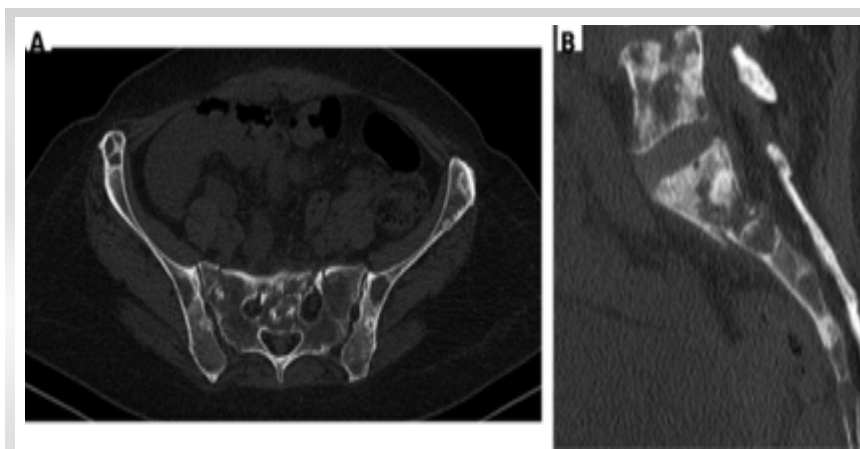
Pre-operative sacral fracture imaging. (a) Axial pelvic computed tomography showing bilateral sacral ala involvement. (b) Sagittal computed tomography reconstruction demonstrating the transverse sacral component, consistent with an H-shaped pathological sacral fracture.
